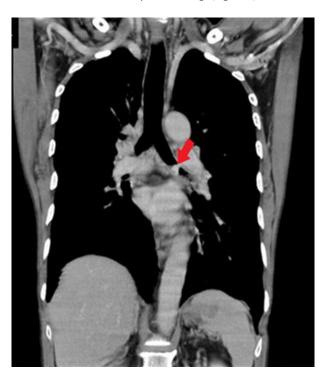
HRCT of thorax (with contrast) showing intrabronchial mass in the left mainstem bronchus (arrow)
